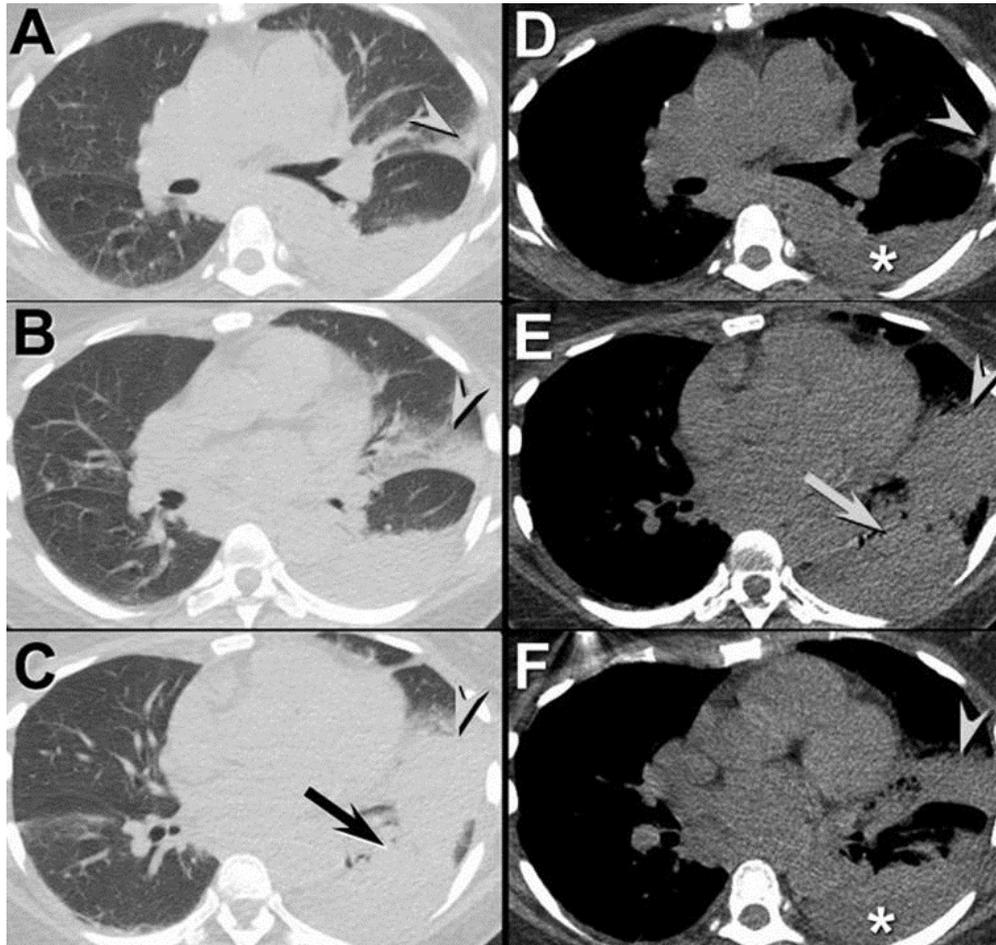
Axial unenhanced thoracic CT shows lingular (arrowheads) and left lower lobe (arrows) consolidation associated with a small left pleural effusion (\*), with minimal nodular opacity in the right upper lobe and mild opacities in the right middle and right lower lobes. No evidence of right pleural effusion is seen. The unenhanced thoracic CT findings confirm the chest radiographic findings.
